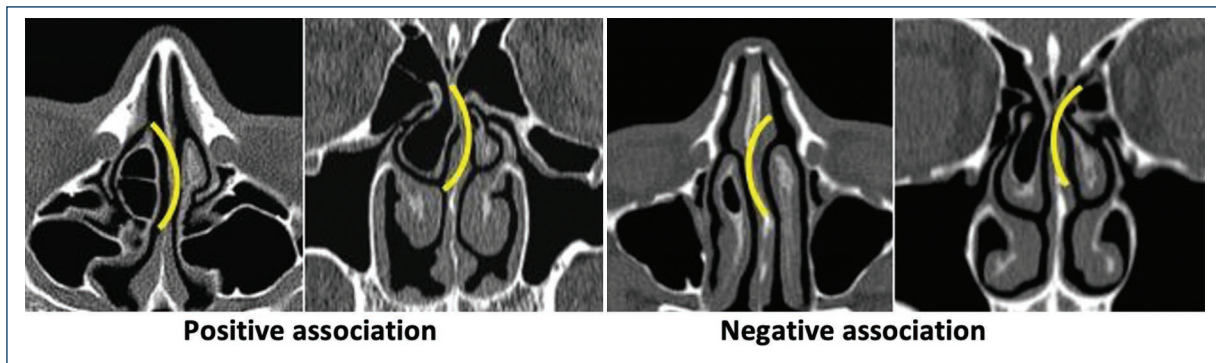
Axial and coronal CT scan images showing the positive and negative association between CB and septal deviation.
